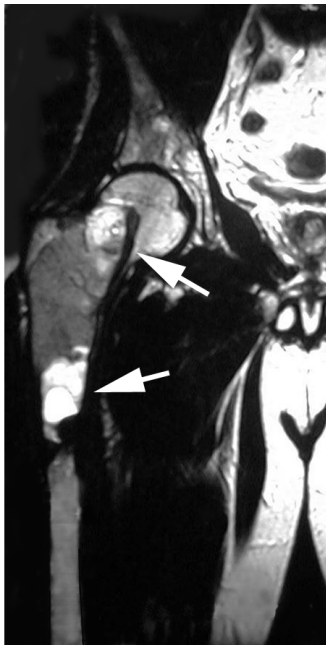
Coronal fat-suppressed T2-weighted MRI scan of the proximal femur. The fibrous component intermixed with bone trabeculae appear as similar or higher in signal intensity than muscle. Cystic degeneration is present in the proximal and distal parts of the fibrous dysplasia (arrows). (Copyright © Rakesh Donthineni-Rao, MD.)
